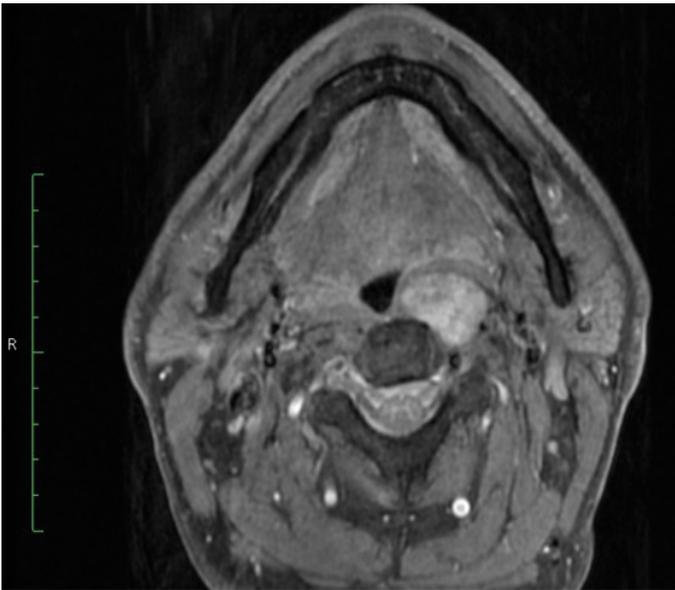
Axial cross-section MR of the head in the T2-weighted sequence after administration of contrast agent – tumor of the posterior wall of pharynx on the left side
